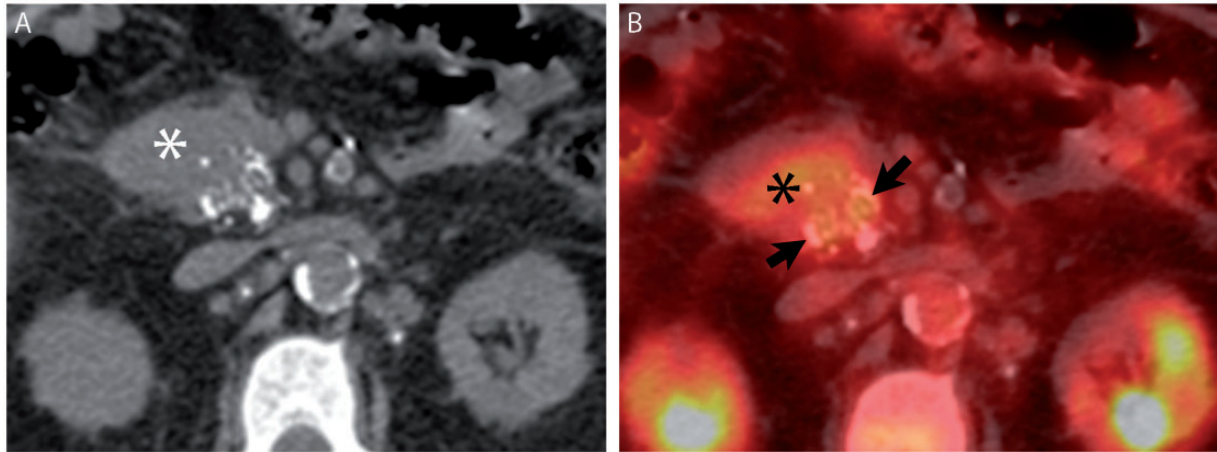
A 68-year-old man with pancreatic ductal adenocarcinoma. (A) Axial noncontrast CT image from [^{18}F]fluorodeoxyglucose (FDG)-positron emission tomography (PET)/CT demonstrates stippled calcification in a pancreatic head mass (asterisk). (B) Fused image from FDG-PET/CT demonstrates FDG avidity engulfing the calcifications (arrows).
